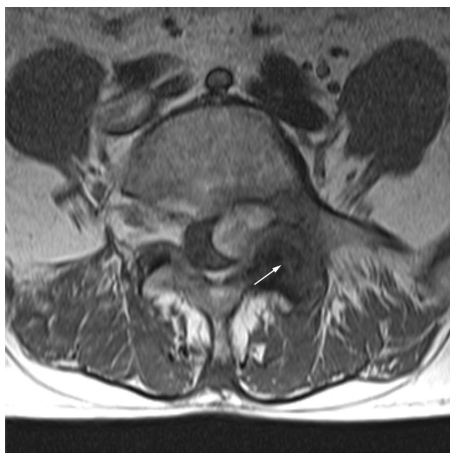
Axial T1- weighted MR image showed a left epidural high intensity lesion at the L5 body level. Axial T1 - (A) and T2- weighted MR image (B) showed a severe degenerative change and dark hypointense lesion at the left L5-S1 facet joint potentially due to deposition of hemosiderin. The same signal intensity of epidural lesion was observed at the Lt. L5-S1 facet joint space (white arrow).
